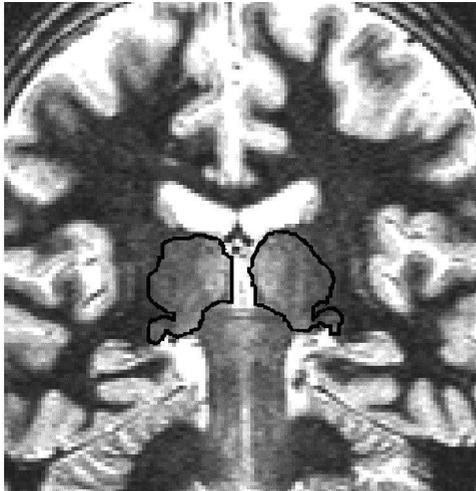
Example of an inversion recovery magnetic resonance imaging scan used for measurement of the thalamus. The scan is a section through the middle level of the thalamus, where it includes the lateral geniculate and medial geniculate nucleus. Left and right thalamus are outlined separately.
